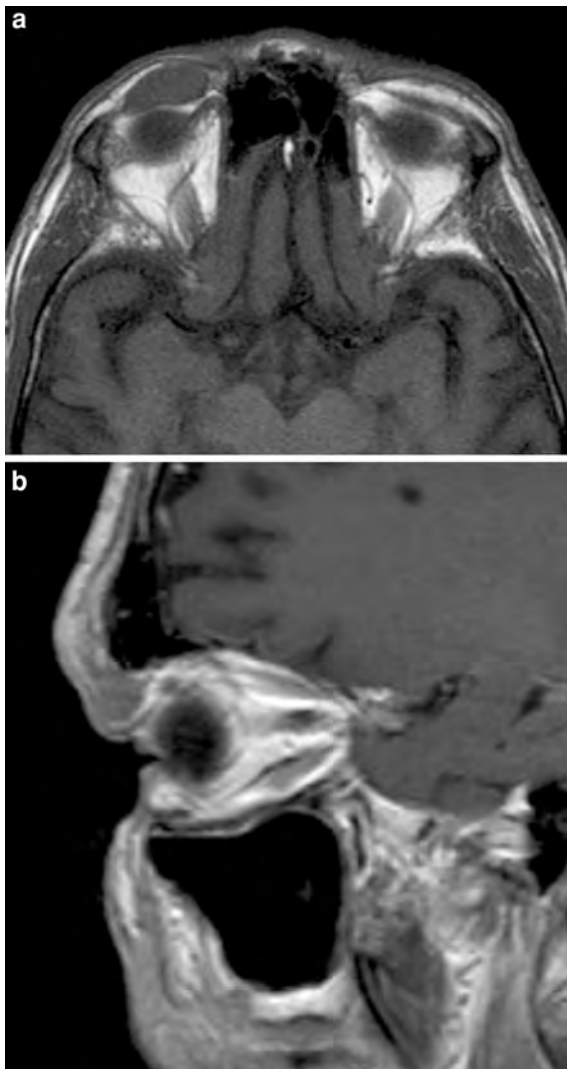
Conjunctival NHL. T1-weighted MR-images. a Axial image at the cranial margin of the orbit shows an ovoid, sharply marginated, lesion located anterior to the right globe. b Post-contrast sagittal image showing mild homogenous enhancement of the mass located in the upper eyelid
